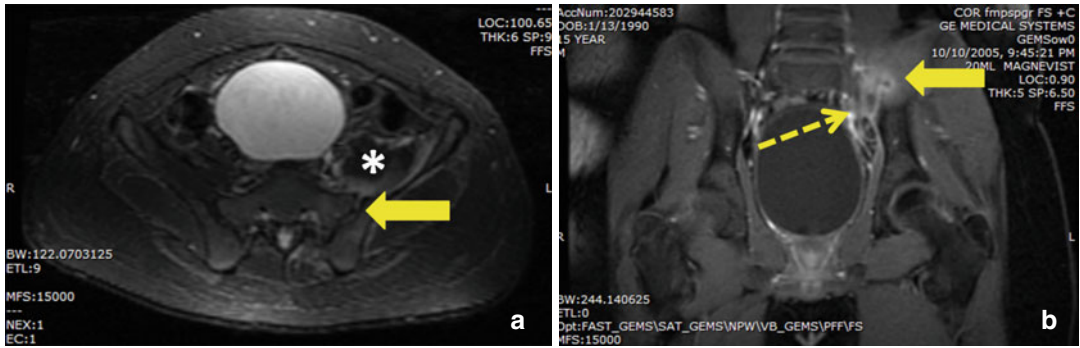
Sacroiliac joint infection with concomitant iliac osteomyelitis and anterior soft tissue abscess in a 14-year-old boy with a 1-week history of progressive buttock/hip pain, increasing fevers, and eventual inability to walk. The axial STIR MR image (a) demonstrates a large anterior
